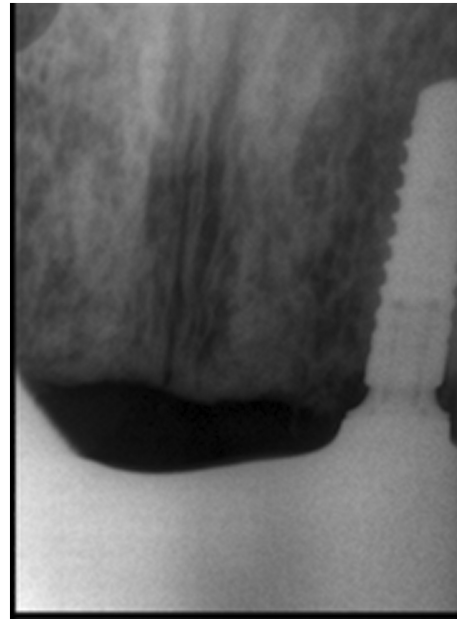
Periapical radiograph showing the final loading of the fixed dental prosthesis on the implant # 22.
